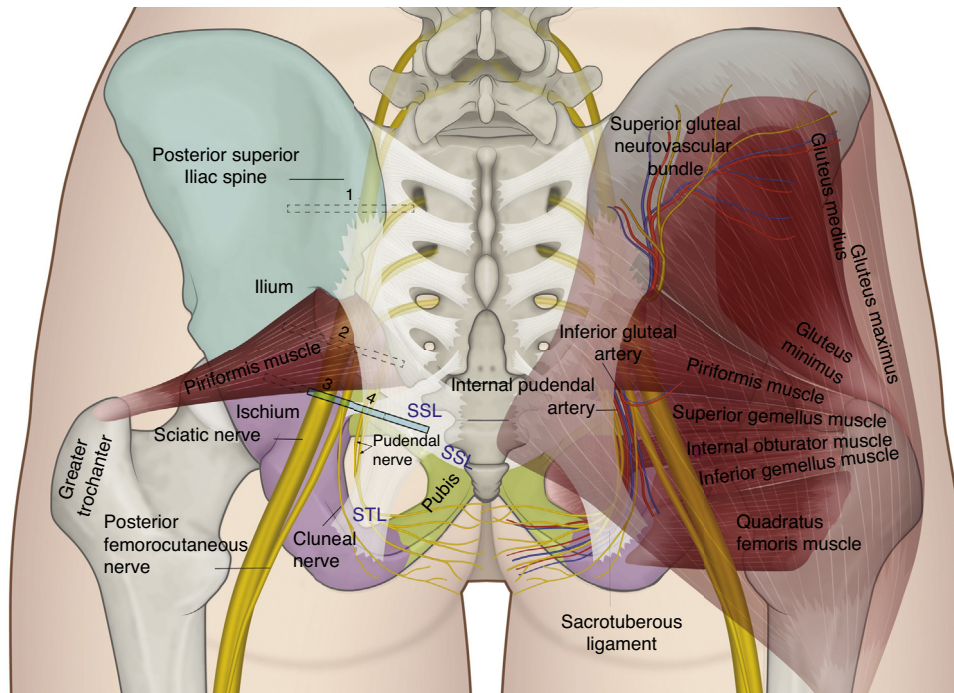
Gluteal anatomy and recommended position for the ultrasound transducer for assessment: (1) at the level of the postero-superior iliac spine; (2) at the level of the greater sciatic foramen; (3) at the level of the ischial spine; and (4) medial to the ischial spine.
